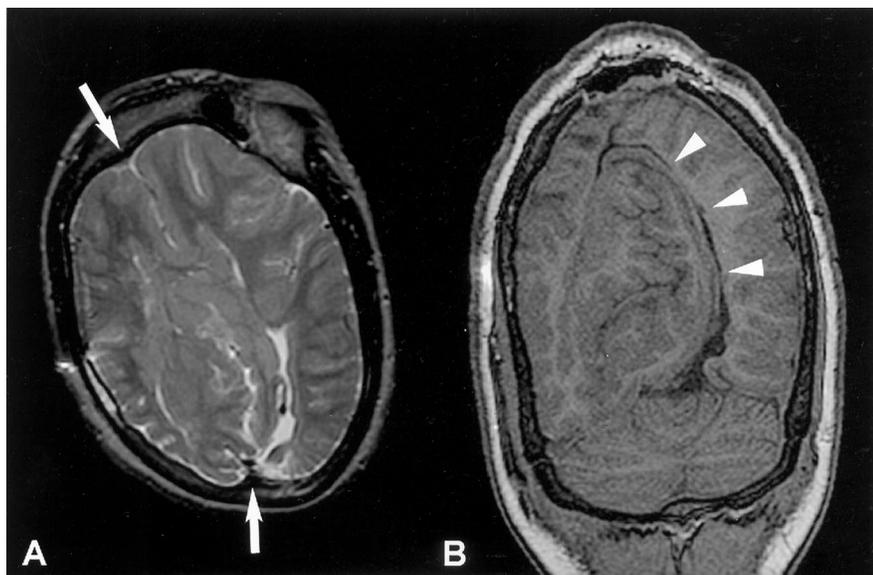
MRI of a patient with lobar holoprosencephaly (HPE). Axial T2-weighted image (A) shows the presence of a nearly complete interhemispheric fissure (arrows) and lateral ventricles. Therefore, this patient was classified as lobar HPE. Coronal three-dimensional spoiled gradient-recalled image (B) shows a large infolding of dysplastic cortex (arrowheads) in the right hemisphere. This patient was severely affected and had intractable epilepsy.
